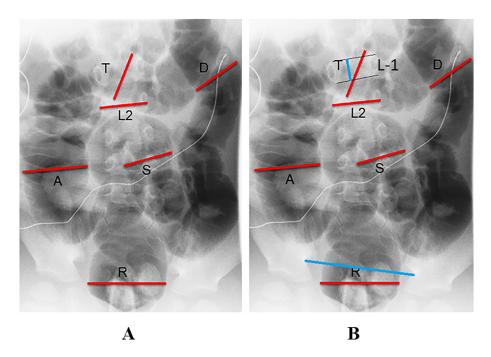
Frontal radiograph from the article. (A) The image from an air contrast enema. Lines indicate characteristics (by authors) that were measured. A—ascending colon diameter, D—descending colon diameter, L-2 width vertebral body, R—rectum diameter, S—sigmoid colon diameter, T—transverse colon diameter. (B) The same radiograph with my additions. The blue line at L-1 is the height of the body L-1. The blue line in the pelvis is the maximal pelvis diameter.
